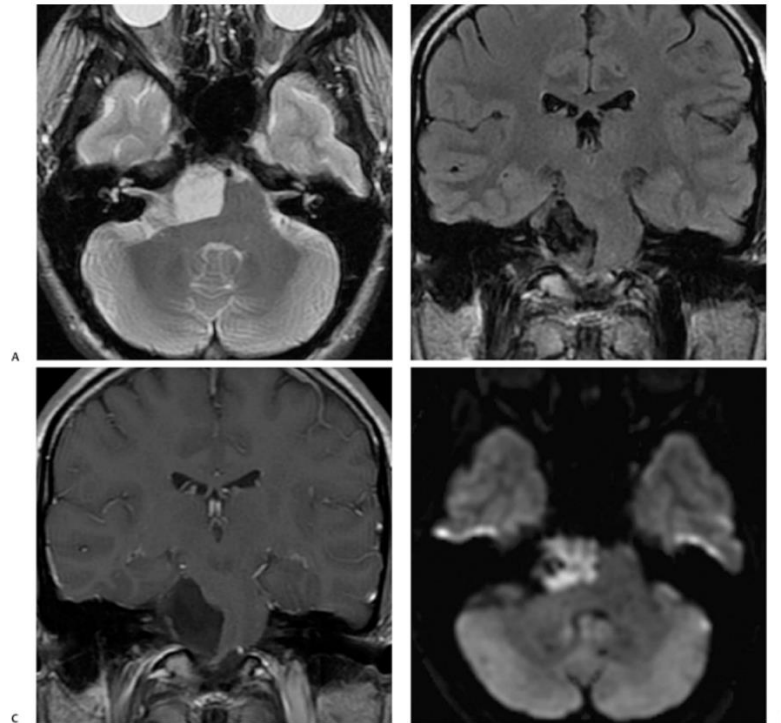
Cerebellopontine angle (CPA) epidermoid in a 19-year-old with an 8-month history of headaches but no hearing loss or facial nerve dysfunction. (A) Axial T2-weighted magnetic resonance image shows the extraaxial hyperintense right CPA mass with no adjacent parenchymal edema. (B) Coronal fluid attenuated inversion recovery (FLAIR) image shows the mass to be hyperintense relative to cerebrospinal fluid. There is no hydrocephalus. (C) Contrast-enhanced T1-weighted magnetic resonance image shows no enhancement. (D) Diffusion weighted image shows restricted diffusion and confirms that there is no extension in the internal auditory canal.
